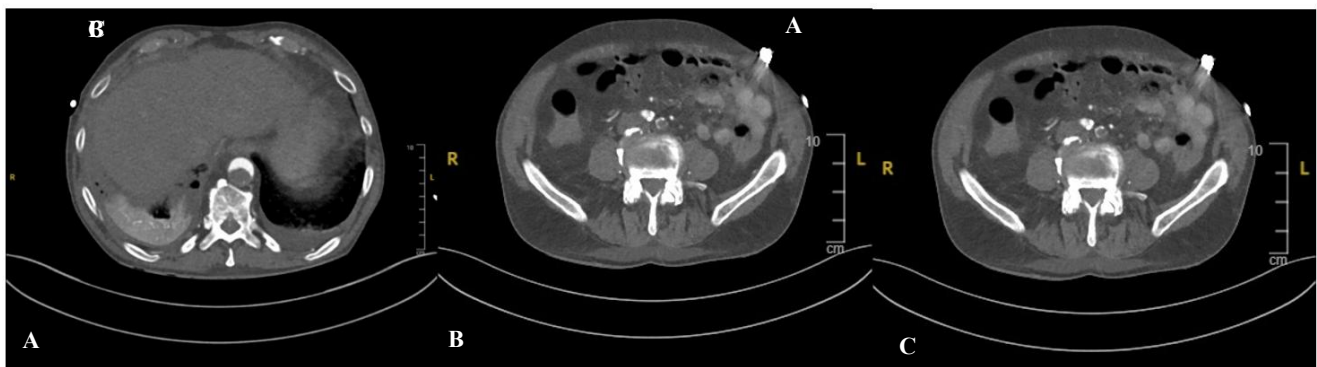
(A) CTA with contrast showing stenosis and thrombosis in the aorta at the level of the diaphragm, (B) near occlusion of the proximal right common iliac artery and (C) moderate to severe stenosis of the right popliteal artery.
